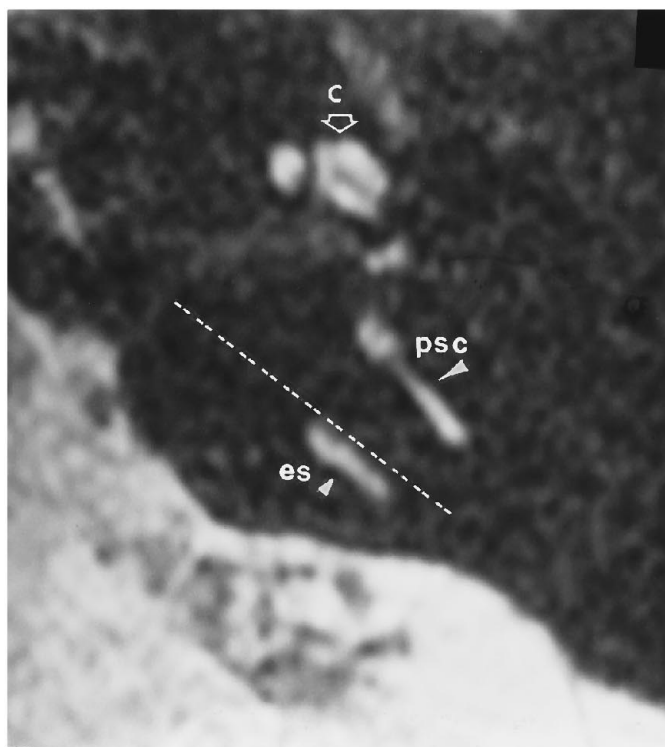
A, Axial high-resolution MR image of the left temporal bone, magnified four times. This is the primary image plane of acquisition. The plane parallel to the endolymphatic sac/vestibular aqueduct (ES) is approximately 45° from the true sagittal plane (dotted white line).
